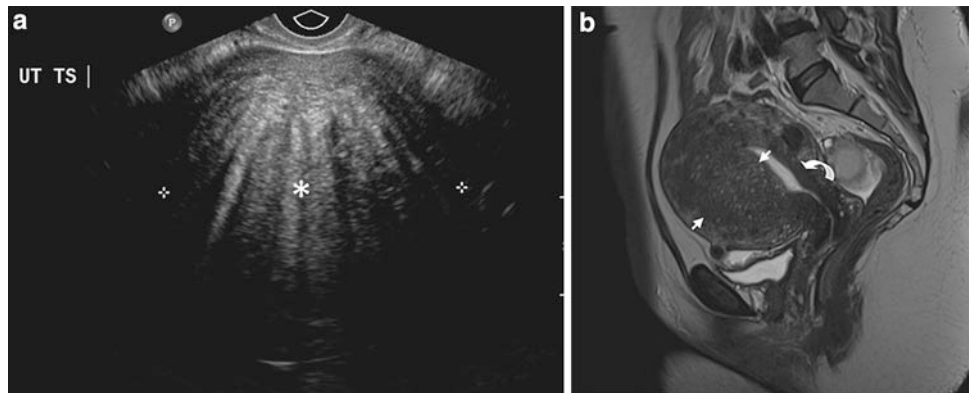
Adenomyosis a TVUS showing what appears to be a heterogeneous circumscribed mass. There are multiple areas of linear posterior shadowing, a typical feature of adenomyosis. b Sagittal T2 weighted MRI confirms myometrial enlargement anteriorly, containing areas of T2 hyperintensity (between *arrow heads*), characteristic of adenomyosis. There is marked widening of the junctional zone anteriorly which is within normal limits posteriorly (*curved arrow*)
